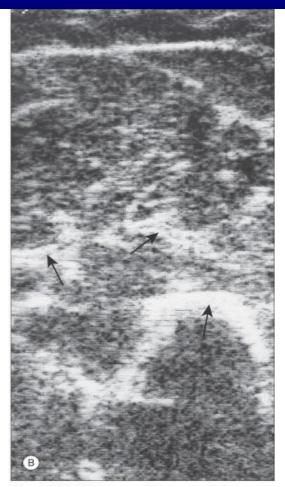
Ultrasound images of the triceps muscle. A Cross-sectional ultrasound image from normal (control) triceps muscle. B Ultrasound image from affected triceps muscle in a patient with dermatomyositis. An increase in interstitial echoes is seen (arrows).
